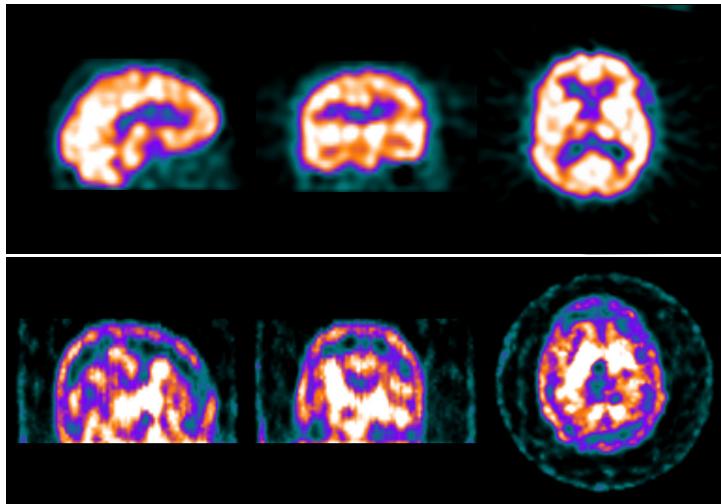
Example of SPECT images, a SPECT-HMPAO and a SPECT-DaTSCAN.
